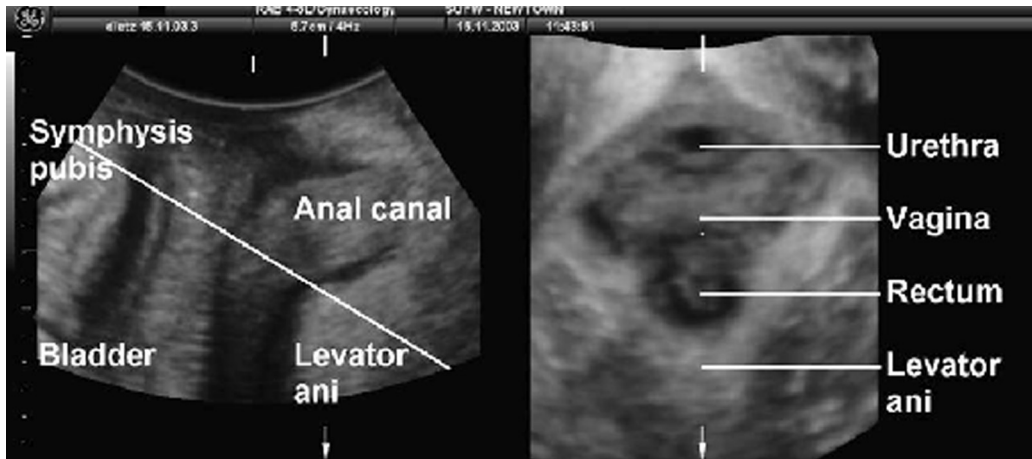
Translabial ultrasound, GE Kretz Voluson 730 expert, 8–4 Mhz volume transducer. The oblique line traversing the midsagittal image on the left represents the axial plane as shown on the right. It is evident that, in order to obtain optimal imaging of the pubovisceral muscle, it is often necessary to use an oblique plane.
